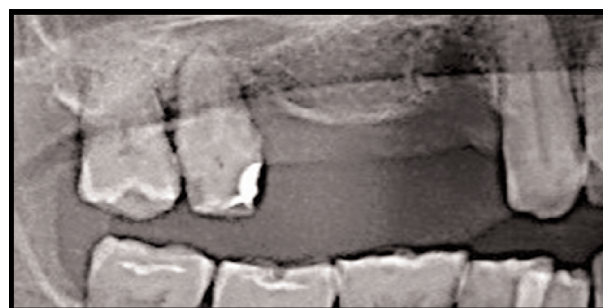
X-ray of the infrabony defect
